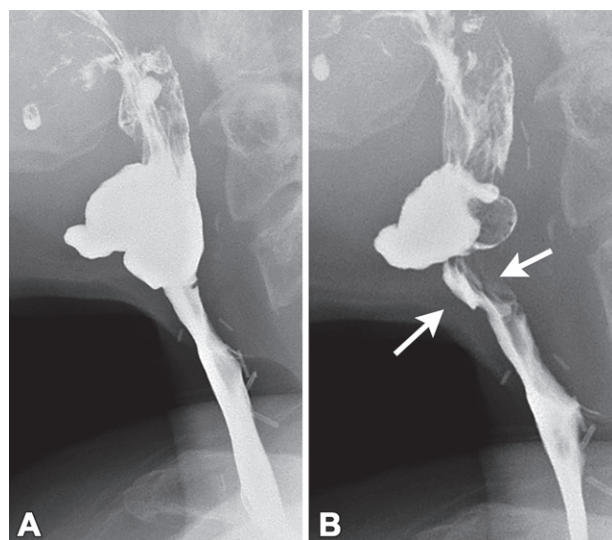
Neopharyngeal dysmotility in a 70-year-old man. Sequential lateral radiographs of swallowing show a premature closure of the neopharynx during the passage of the bolus (arrows in B), with residue in the proximal lumen.
